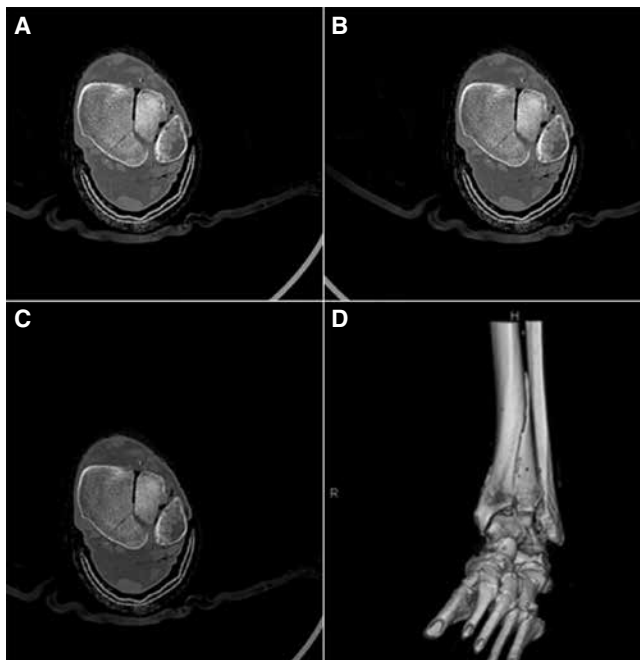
Panels A–C represent axial CT cuts at 120 KvP through a distal tibia utilizing progressively lower doses of radiation (110, 60 and 45 mAs, respectively). Panel D represents a 3D volume rendered (3dVRT) reconstruction, also available to reviewers.
